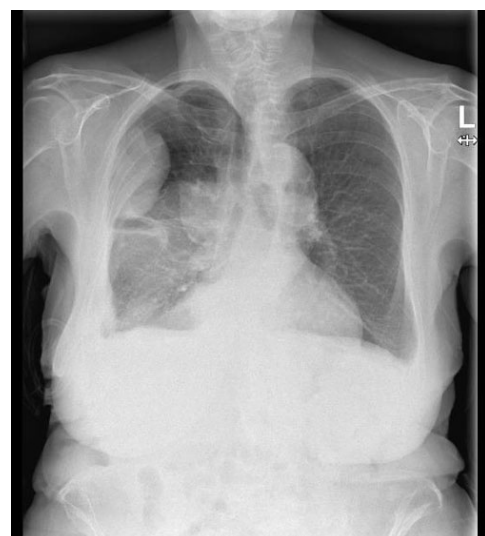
Chest radiograph a few weeks later showing full resolution of the surgical emphysema.
